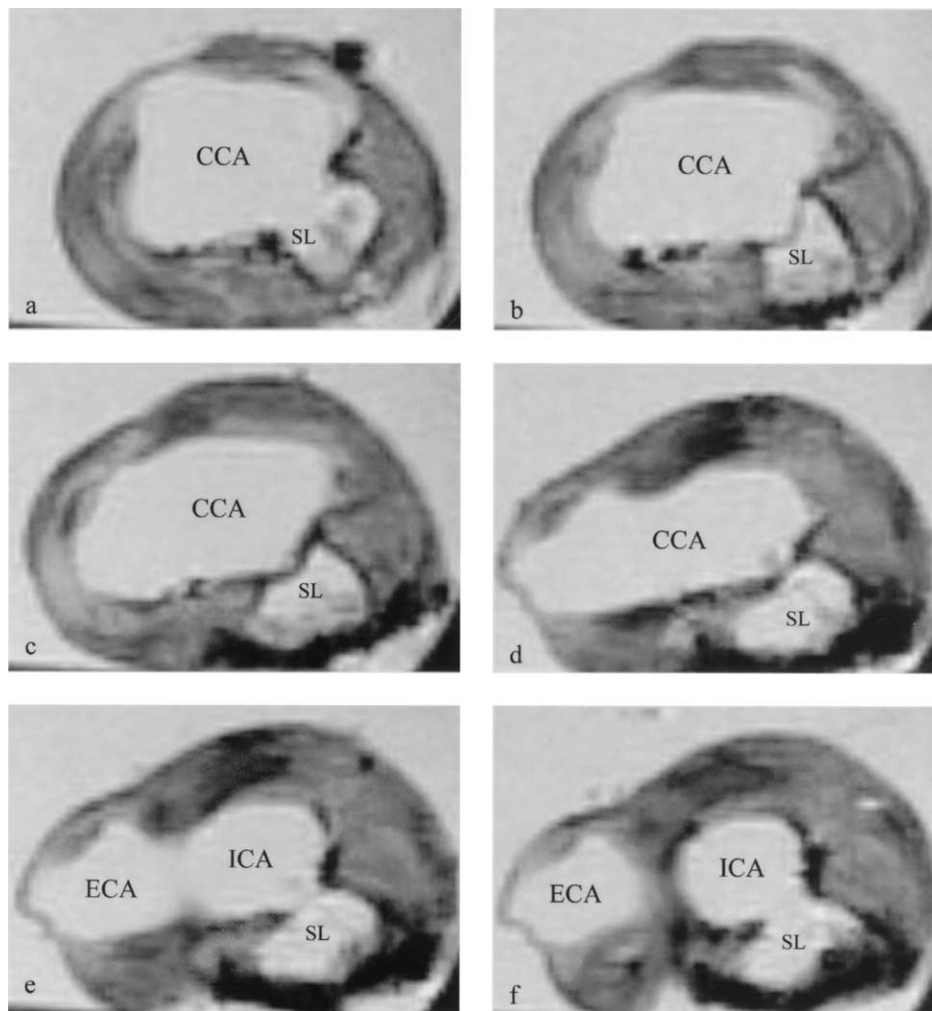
Serial sections through high-resolution MRI images of plaque show a second lumen beginning in the distal common carotid artery (CCA) and reopening at the level of the internal carotid artery (ICA) orifice. SL, Single lumen.
